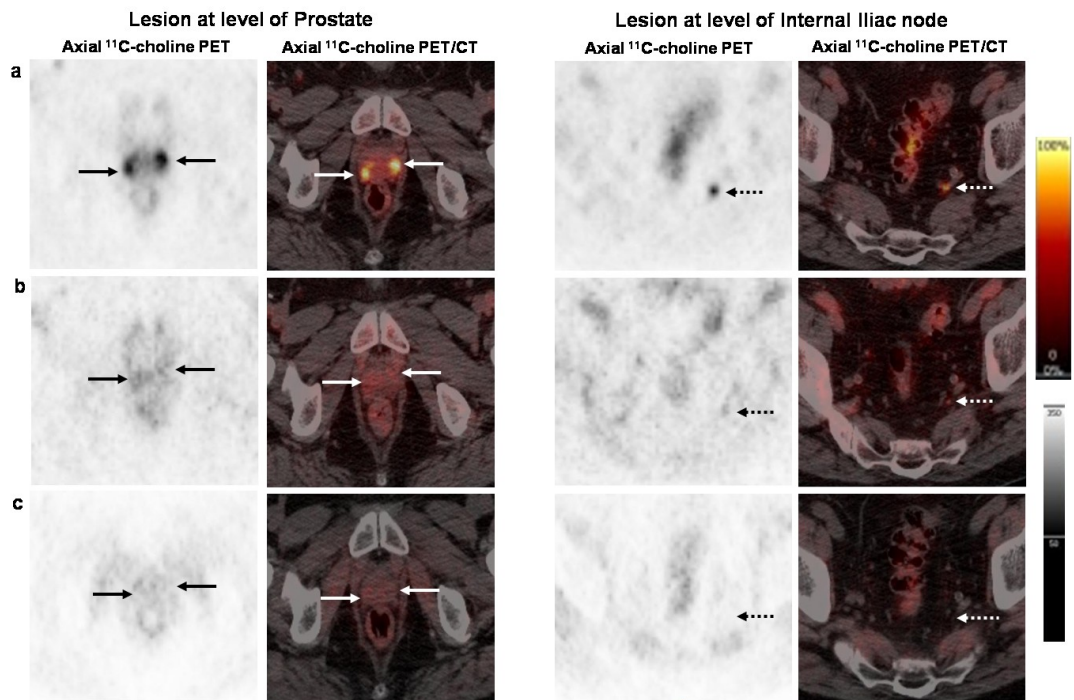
Axial [¹¹C]choline PET and fused PET/CT at the level of prostate and left internal iliac node.
